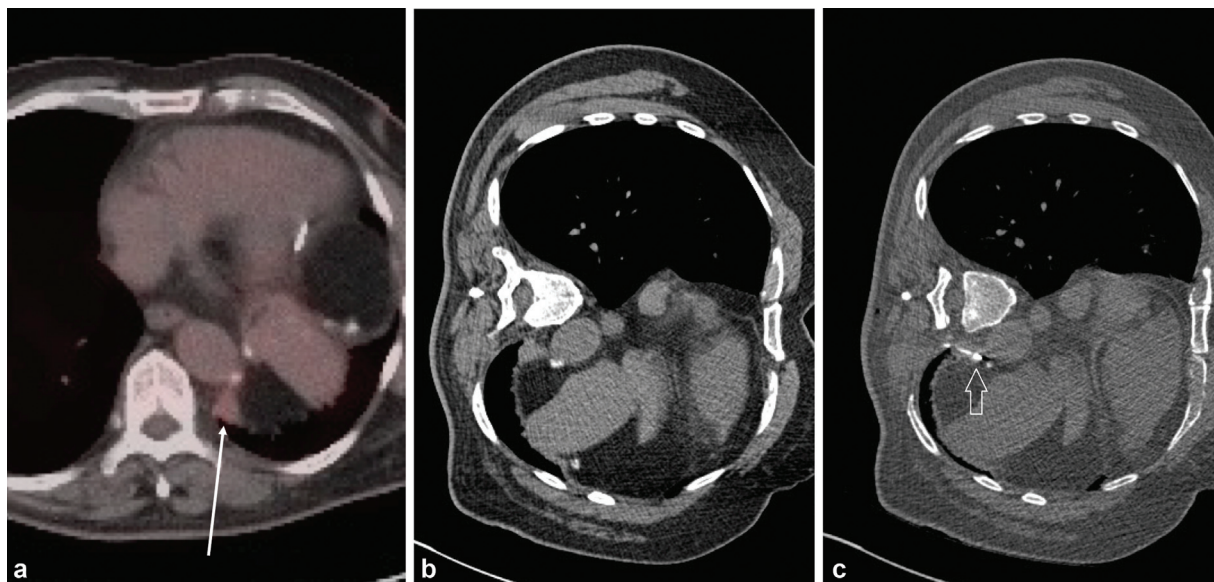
A 73-year-old with a history of thymoma presents with new left pleural lesion which was mildly avid on PET-CT (a, arrow). Biopsy was performed in the left lateral decubitus position (b and c; arrow—needle tip) avoiding lung. Pathology demonstrated thymoma.
